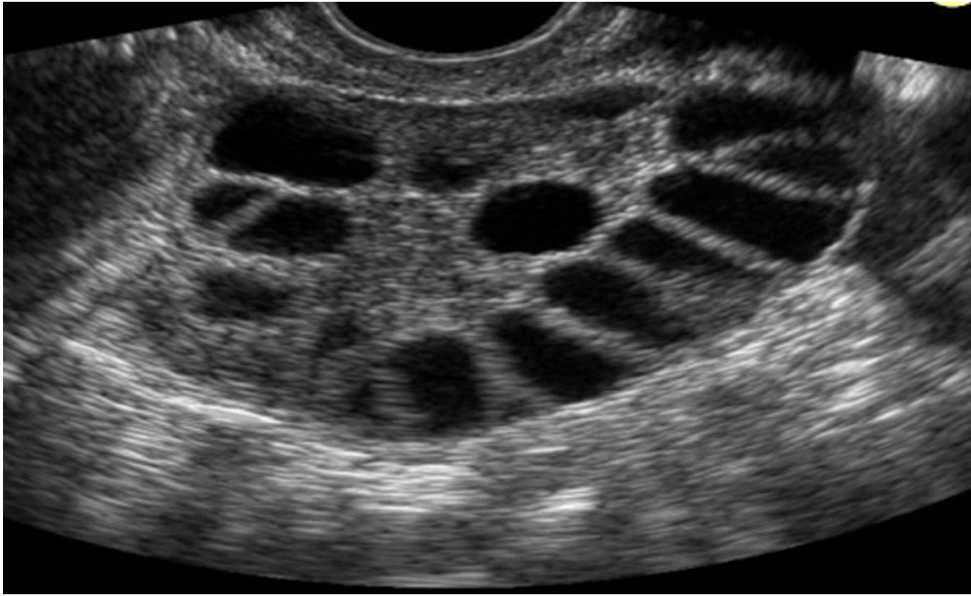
Shows Transvaginal ultrasound image of poly cystic ovarian disease of 35 years patient
